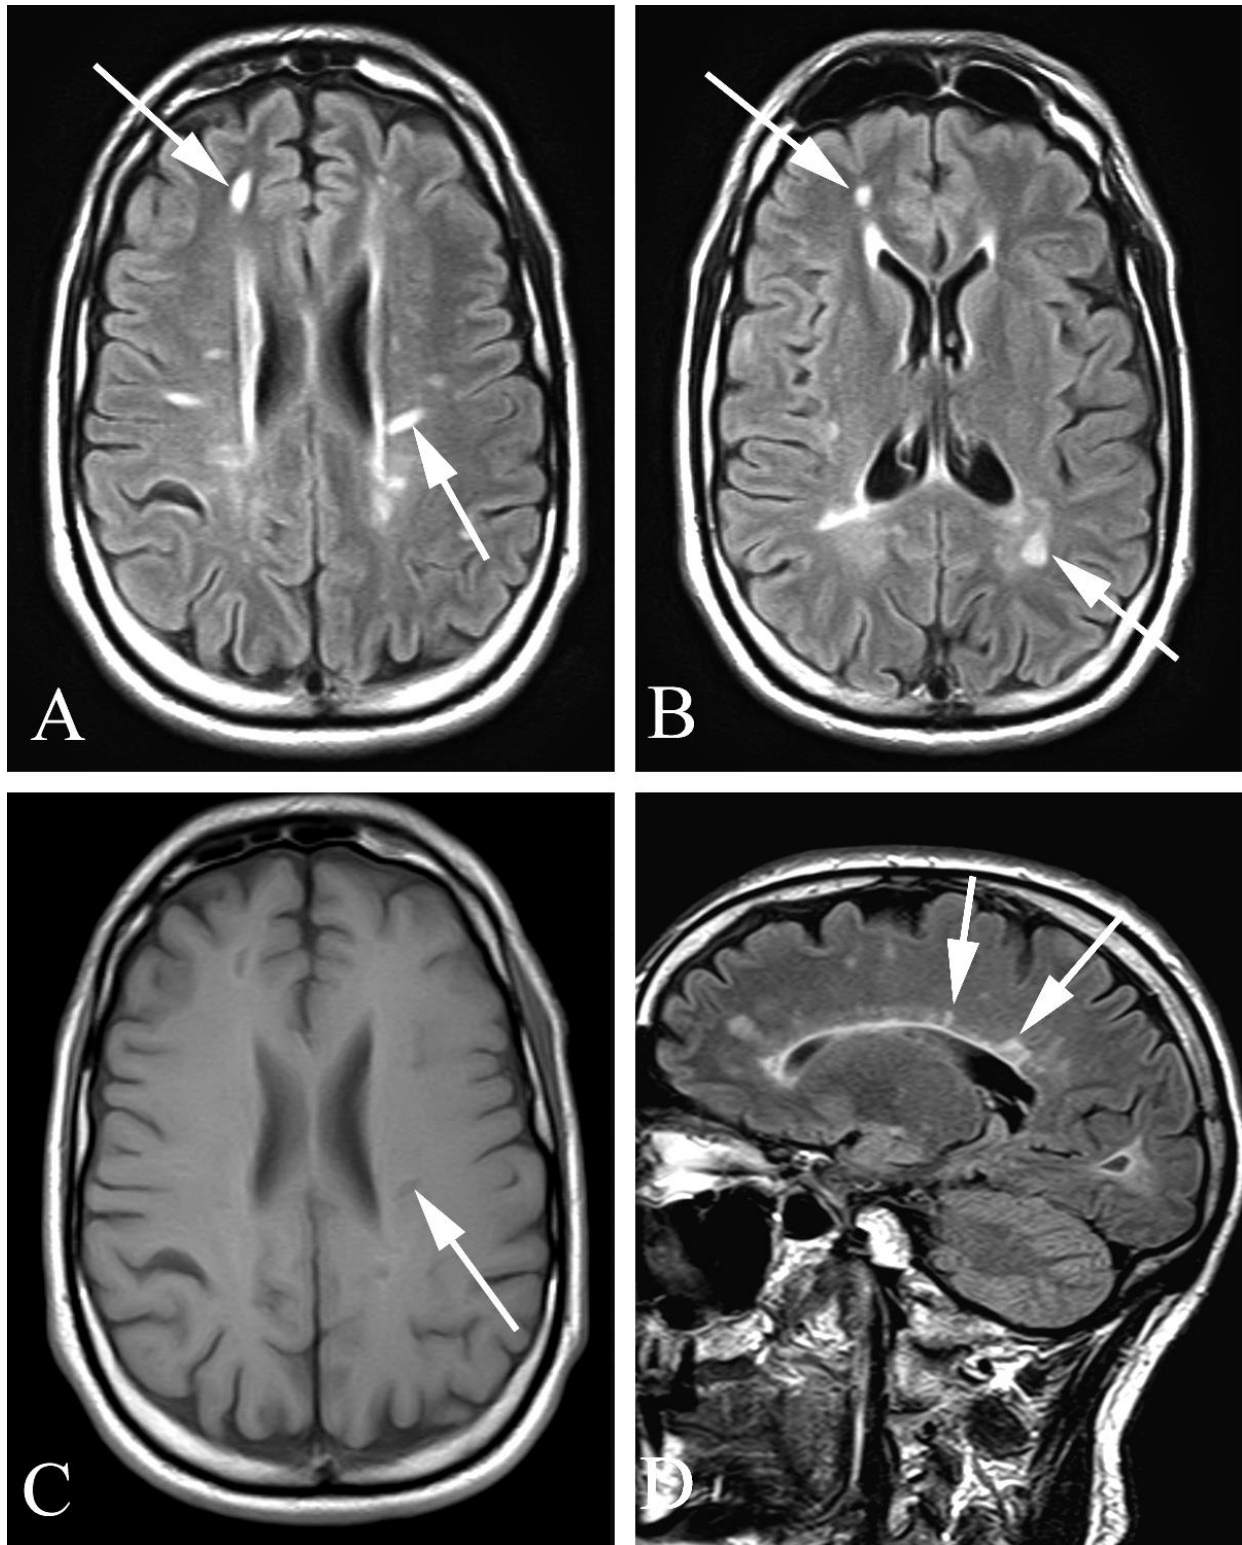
Multiple sclerosis in a 52 year old man with new onset poor coordination of the lower extremities. A Axial FLAIR brain MR shows multiple foci increased signal intensity (arrows). B. Axial FLAIR brain MR at a slightly lower location again shows multiple foci of increased signal intensity (arrows). C. Axial T1 weighted image shows decreased signal intensity at the location of the increased signal on B. D. Sagittal FLAIR brain MR shows multiple lesions of the corpus callosum (arrows), typical of multiple sclerosis.
